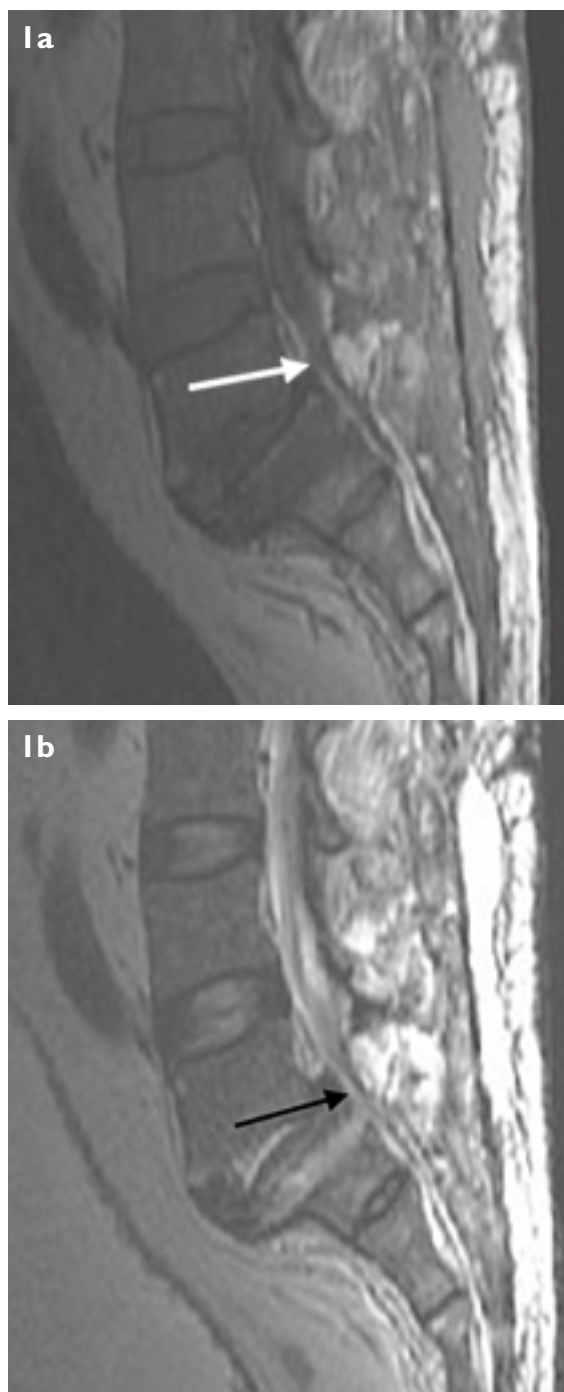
Sagittal MR images show severe constriction (arrow) of the lumbosacral dura sac by a posterior mass. The mass has (a) mixed high and low signal intensity on T1-W and (b) high signal intensity on T2-W images.
